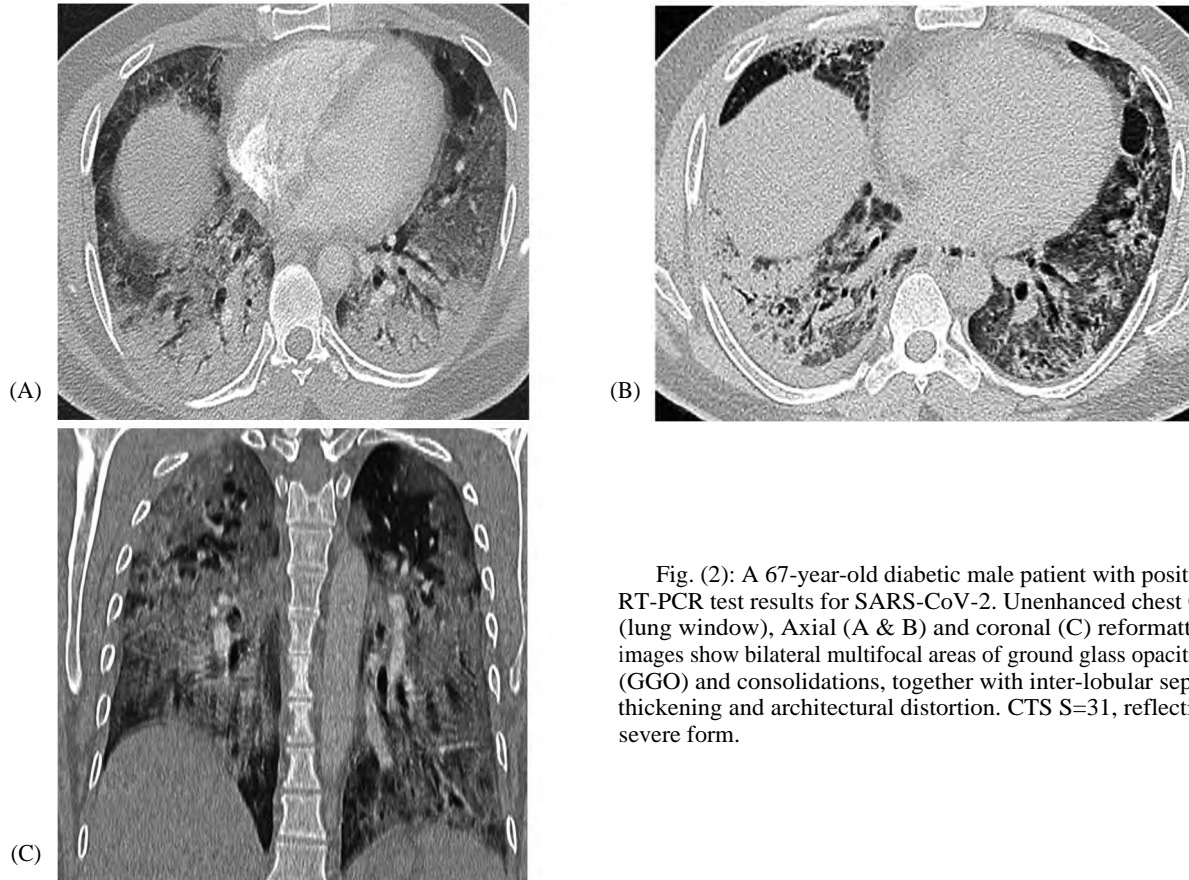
A 67-year-old diabetic male patient with positive RT-PCR test results for SARS-CoV-2. Unenhanced chest CT (lung window), Axial (A & B) and coronal (C) reformatted images show bilateral multifocal areas of ground glass opacities (GGO) and consolidations, together with inter-lobular septal thickening and architectural distortion. CTS S=31, reflecting severe form.
